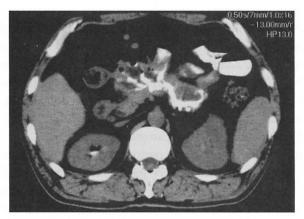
Abdominal CT showed the reduced pancreatic abscess. Contrast medium was recognized in the small intestine and the abscess cavity.
